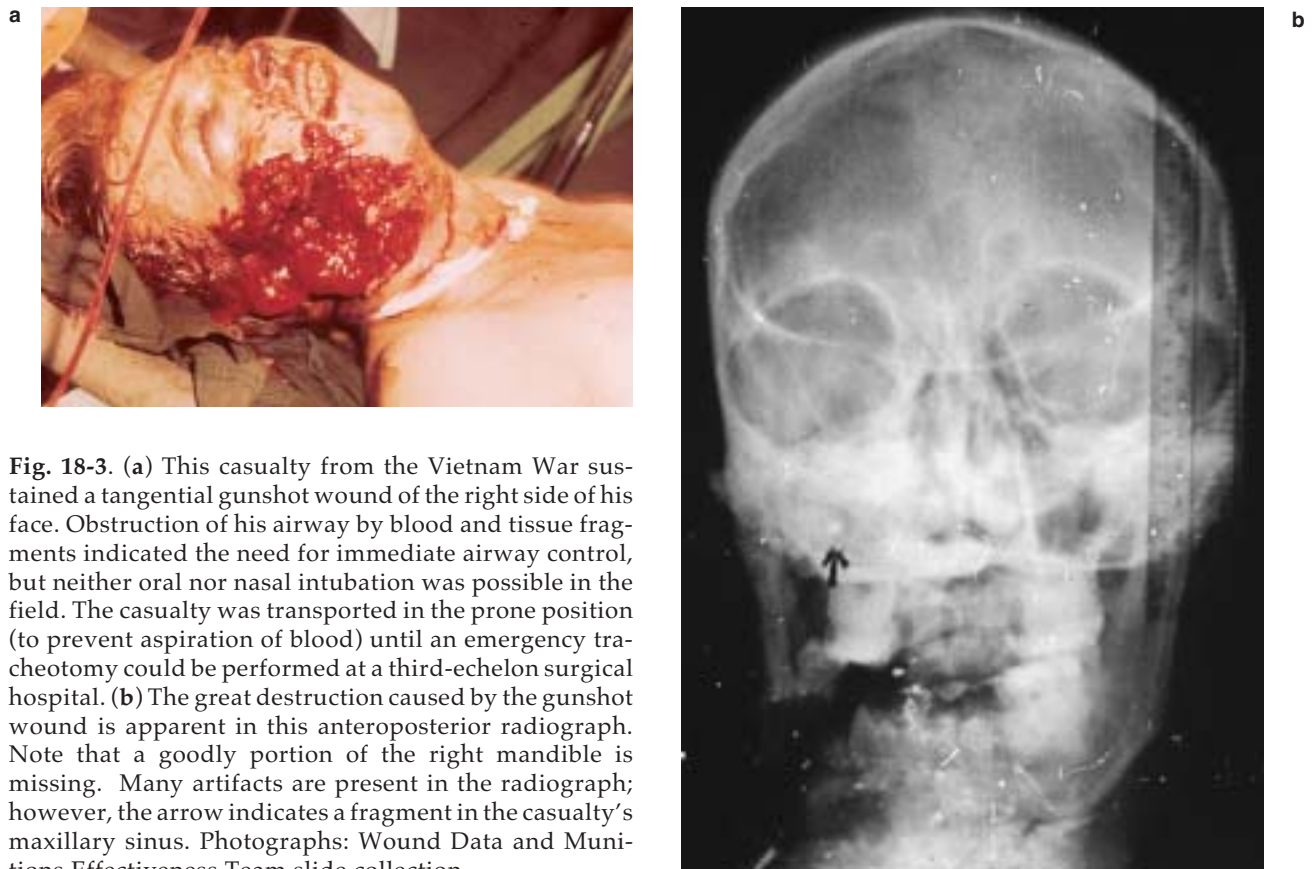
(a) This casualty from the Vietnam War sustained a tangential gunshot wound of the right side of his face. Obstruction of his airway by blood and tissue fragments indicated the need for immediate airway control, but neither oral nor nasal intubation was possible in the field. The casualty was transported in the prone position (to prevent aspiration of blood) until an emergency tracheotomy could be performed at a third-echelon surgical hospital. (b) The great destruction caused by the gunshot wound is apparent in this anteroposterior radiograph. Note that a goodly portion of the right mandible is missing. Many artifacts are present in the radiograph; however, the arrow indicates a fragment in the casualty's maxillary sinus. Photographs: Wound Data and Munitions Effectiveness Team slide collection.
